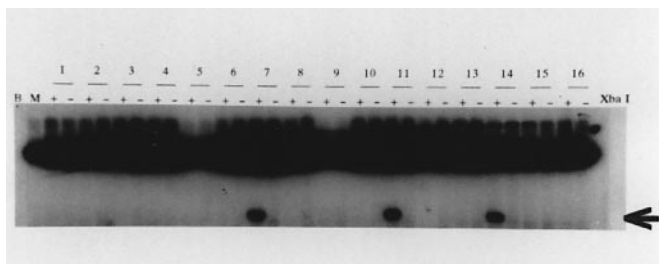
Detection of *Ha-ras* codon 61 CAA→CTA mutation by PCR/RFLP method. The mutation produces a Xba I site in amplified 116-bp DNA fragment. Upon separation of the Xba I-digested product in 6% polyacrylamide gel, the presence of a 80-bp band (arrow) serves as a diagnostic marker for the mutation. PCR products were labeled with tracer amount of α -[³²P]dCTP and detected by autoradiography. Lane B, blank without template DNA; lane M, normal mammary gland DNA as a negative control; lane 1-16, mammary adenocarcinomas DNA. + and -, 5 μ l of PCR product treated with or without 5 units of Xba I, respectively.
